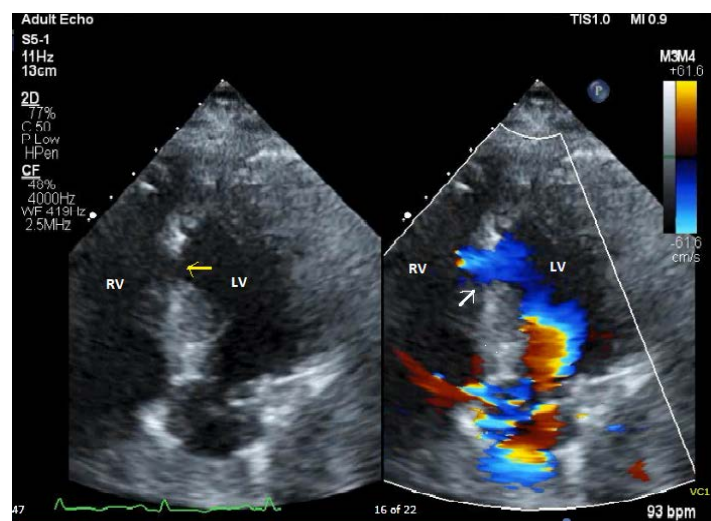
Postoperative transthoracic ECHO revealed new mid-inferior VSR diagnosed by left to right shunt (white arrow) in doppler mode and loss of septal integrity in M mode (yellow arrow). LV: left ventricle, RV: right ventricle.
